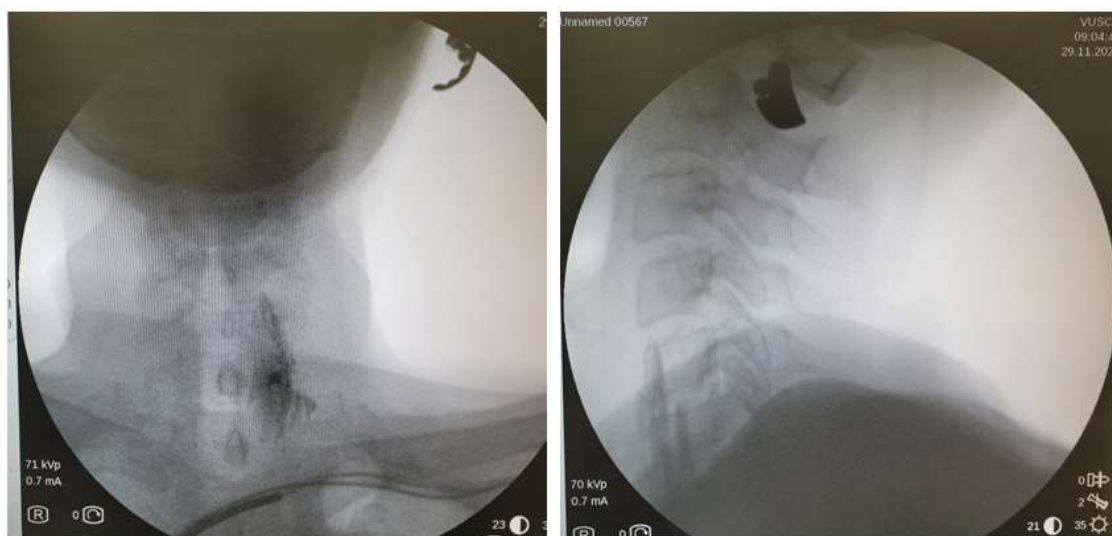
Spread of the contrast in the stellate ganglion area, X-ray control AP and lateral projections (Author's archives).
